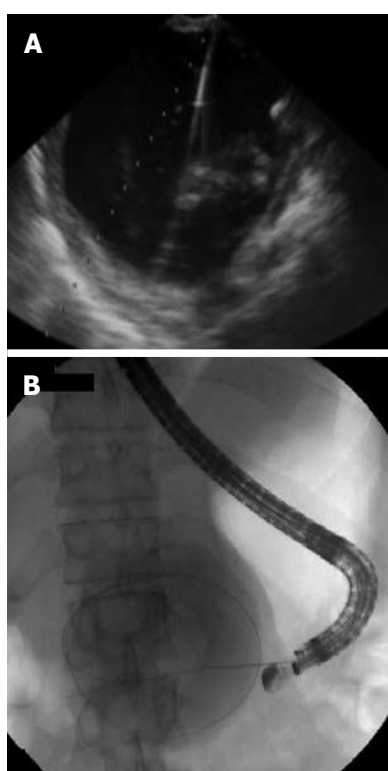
Needle puncture of the pancreatic fluid collection and insertion of a guide-wire. A: Ultrasonographic image of needle puncture of the pancreatic fluid collection; B: Radiological image of insertion of a guide-wire in the pancreatic fluid collection.
